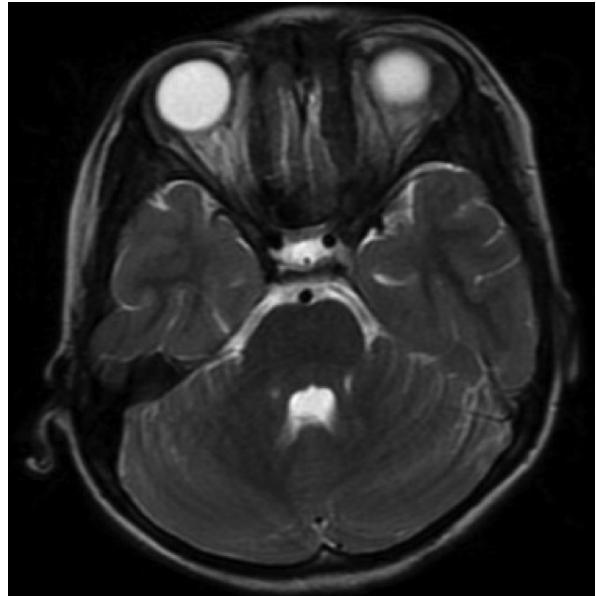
Brain MRI showing no leptomeningeal enhancement
